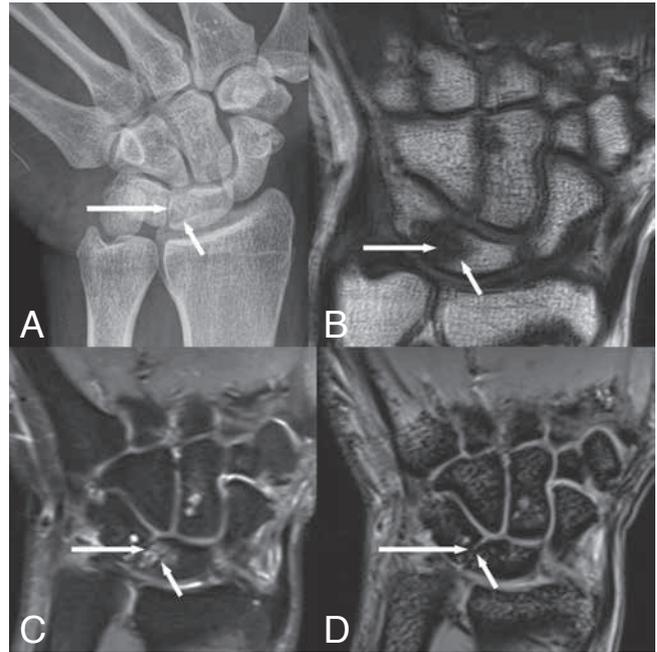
LTC type 1 (patient 1). A. Plain radiography, B. Coronal SE T1-WI, C. Coronal SE T2-WI and D. Coronal 3D-GRE. A. The LTJ is narrowed with irregular margins (long arrow) and subchondral cysts (short arrow). B, C and D: The LTJ is filled with fibrovascular tissue (long arrows). There is oedema (B, C, short arrows) surrounding a subchondral cyst (C) (short arrow) and the margins are irregular (D) (short arrow).
